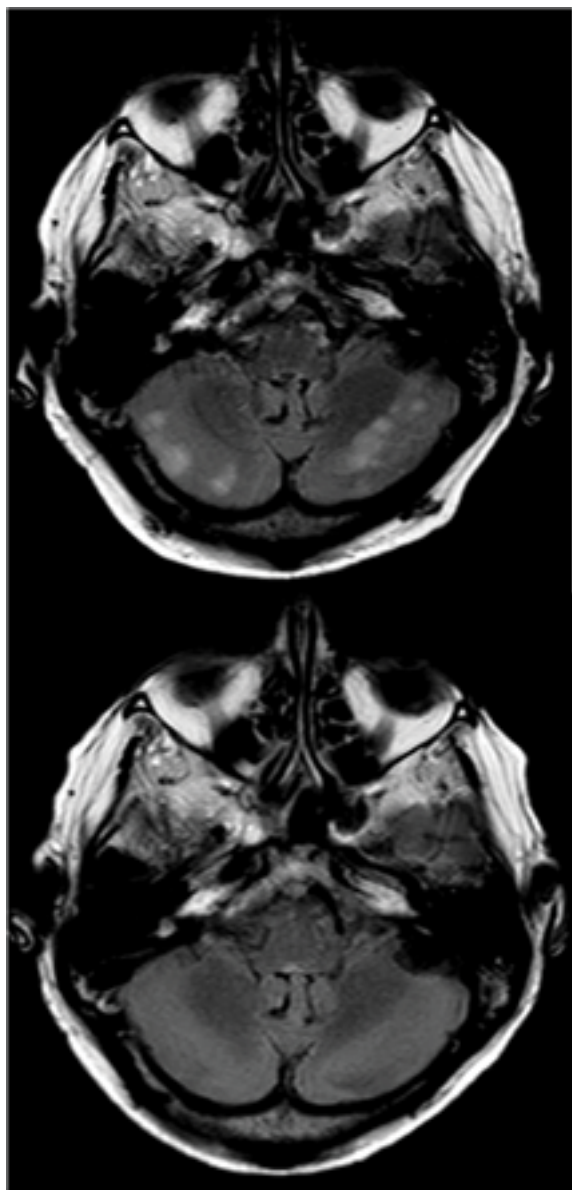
MRI (fluid attenuated inversion recovery): acute cerebellar vasogenic oedema involving bilateral temporo occipital and cerebellar regions consistent with PRES.
